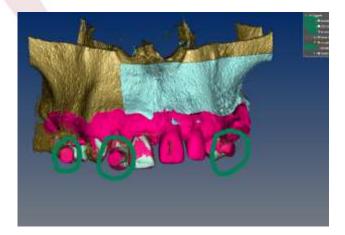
Matching devices: Radio opaque markers and radiographic stents, used in both intra-oral and radiological scans, make it possible to spatially align the 3D
